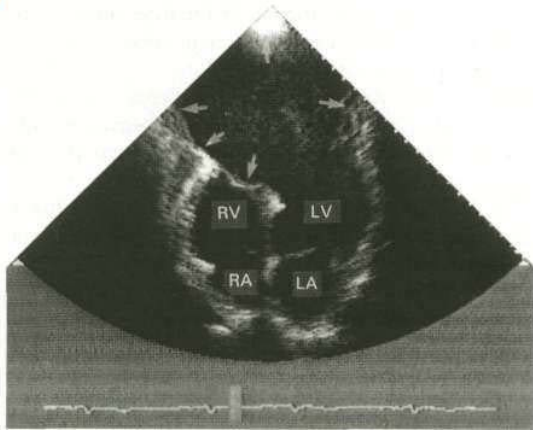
Two-dimensional echocardiogram (apical four-chamber view) showing a very large apical left ventricular aneurysm (arrowed). The relatively static blood in the aneurysm produces a swirling 'smoke' effect. This aneurysm was successfully resected surgically. LV, left ventricle; LA, left atrium; RV, right ventricle; RA, right atrium.
